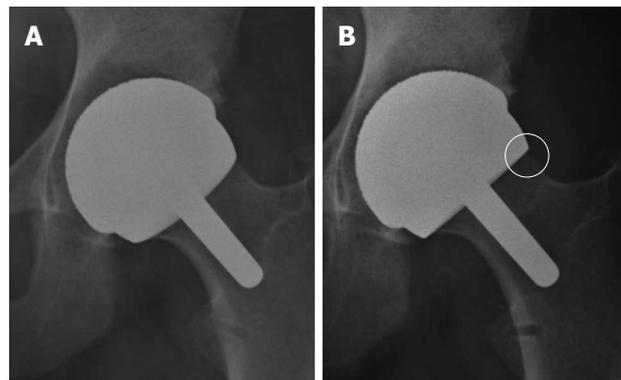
Femoral neck narrowing after Birmingham metal-on-metal hip resurfacing prosthesis occurs as early as 3 mo postoperatively and the neck-to-prosthesis ratio stabilizes thereafter. A: Immediate postoperative X-ray; B: Circle showing neck narrowing at 3 mo postoperatively.
